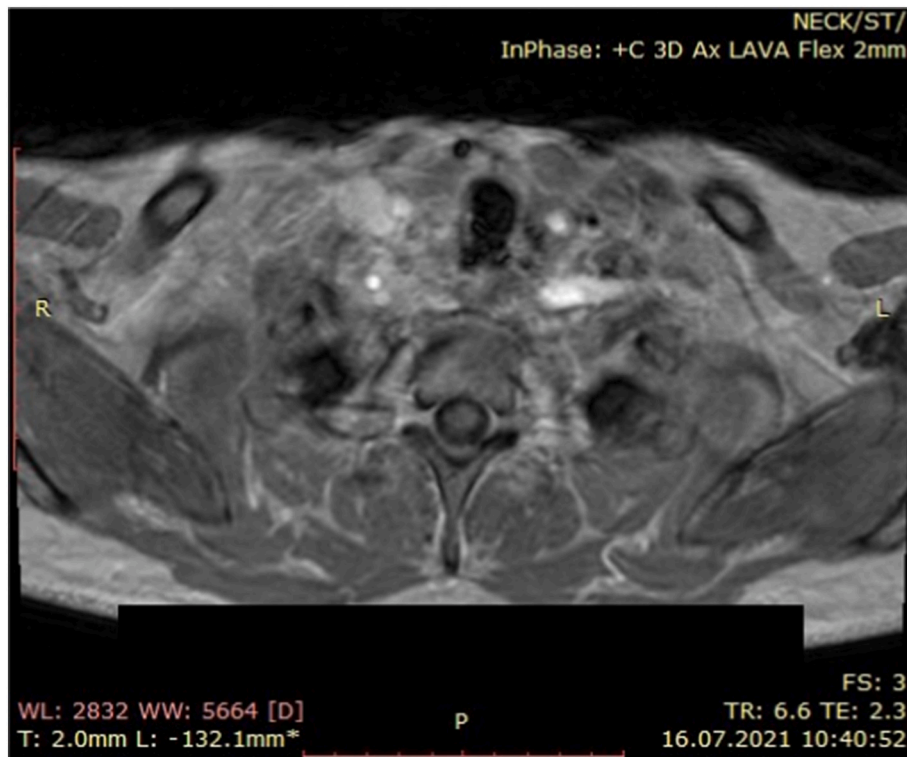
MRI, six months later. There is no evidence for relapse.
